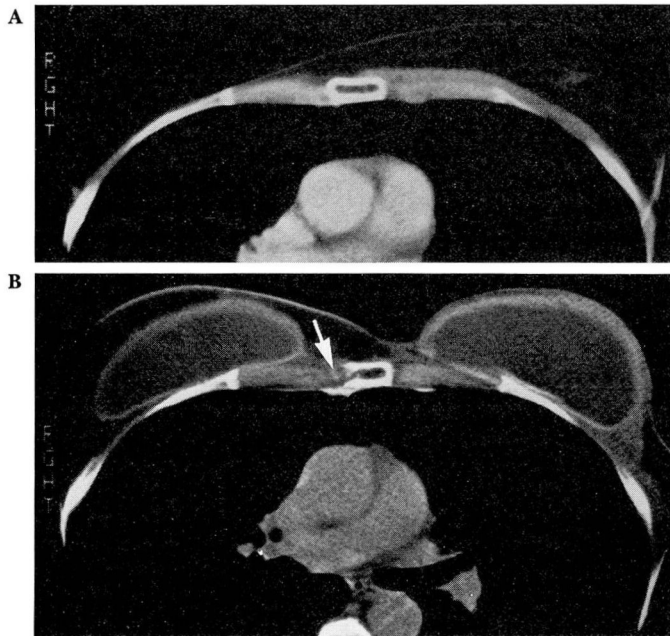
A. High-resolution CT scan of the anterior chest wall after right mastectomy for breast carcinoma.
